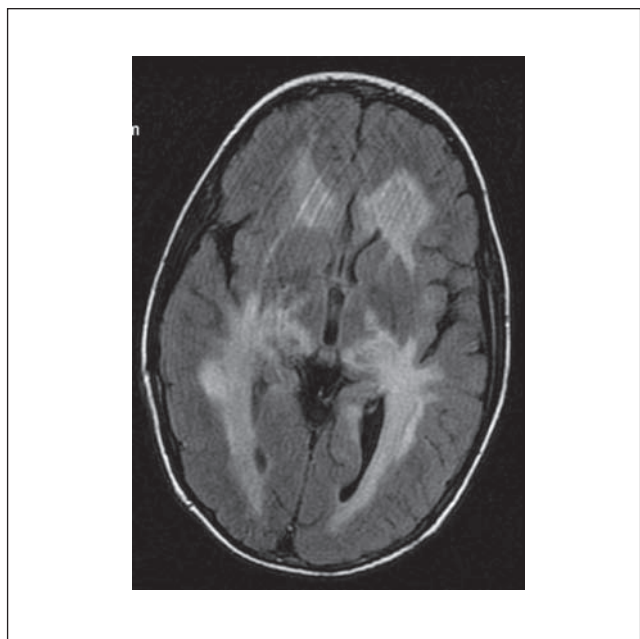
A 10-year-old boy with a characteristic MR appearance of X-linked adrenoleukodystrophy which was confirmed after MRI.
